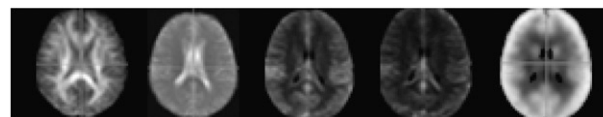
(From left) Mean FA, MD, CBF, CBV, and FDG images
